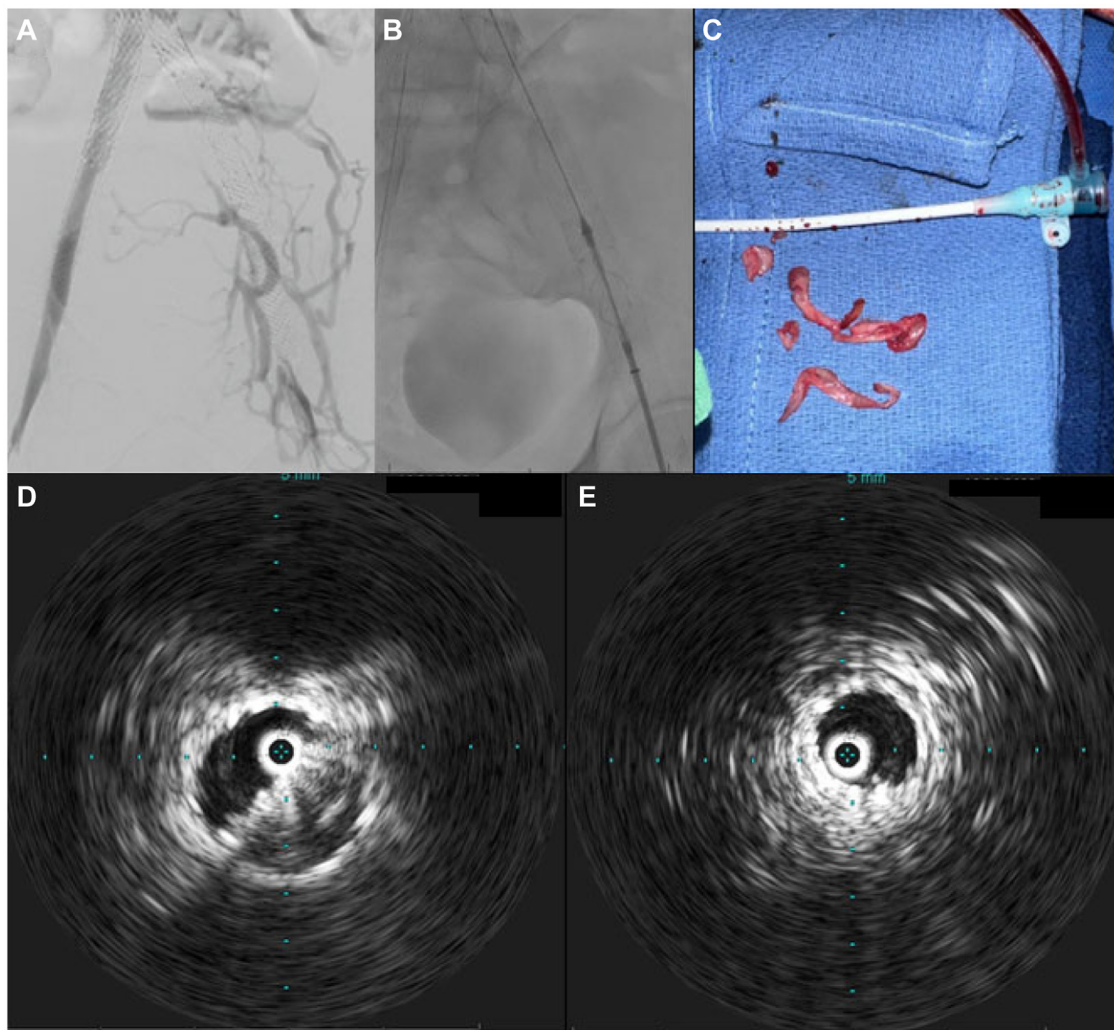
Operative venogram sequence showing left external iliac vein (EIV) and common iliac vein (CIV) stent occlusion (A). RevCore system positioned in the left EIV stent (B). Extraction of thrombotic material inside the stent (C). Intravascular ultrasound (IVUS) images of luminal gain after thrombectomy with for the left CIV stent at the inferior vena cava (IVC) confluence (D) and left EIV stent (E).
